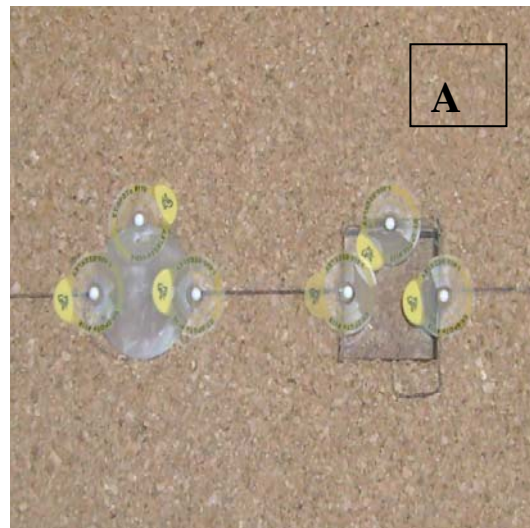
A Radio opaque markers (BBs) on the leading edge and center of each target. B Edge and center position (measured with respect to CT zero position) on each phase is equally distributed throughout all phases as we expect from the real target.
